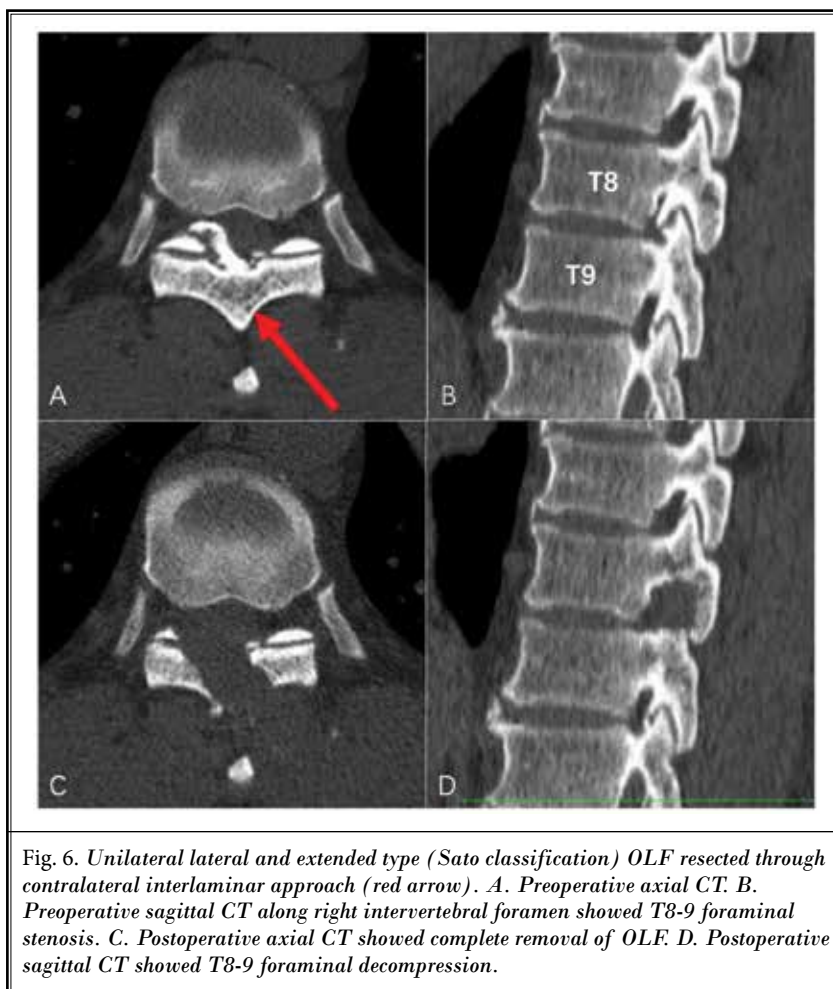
Unilateral lateral and extended type (Sato classification) OLF resected through contralateral interlaminar approach (red arrow). A. Preoperative axial CT. B. Preoperative sagittal CT along right intervertebral foramen showed T8-9 foraminal stenosis. C. Postoperative axial CT showed complete removal of OLF. D. Postoperative sagittal CT showed T8-9 foraminal decompression.
